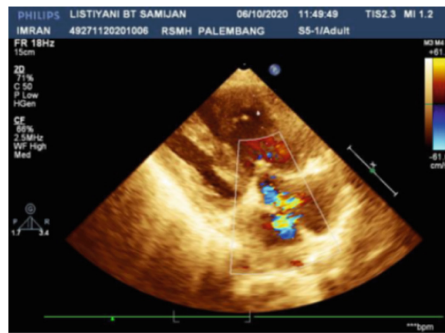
Echocardiography showed atrialseptal defect left to right shunt.
